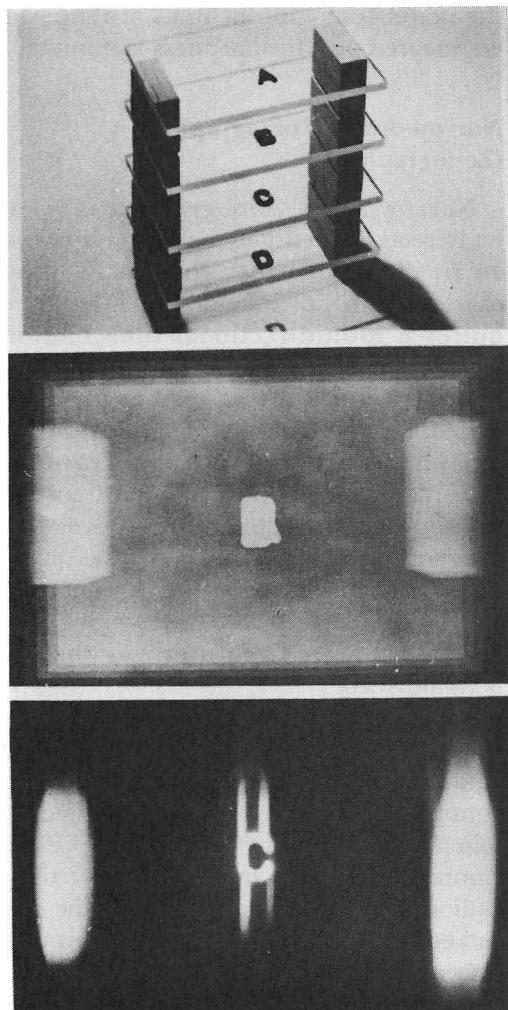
Extended visibility with wide-angle tomography. (The Fundamentals of Radiology. Rochester, NY, Eastman Kodak, Radiography Markets Division)
